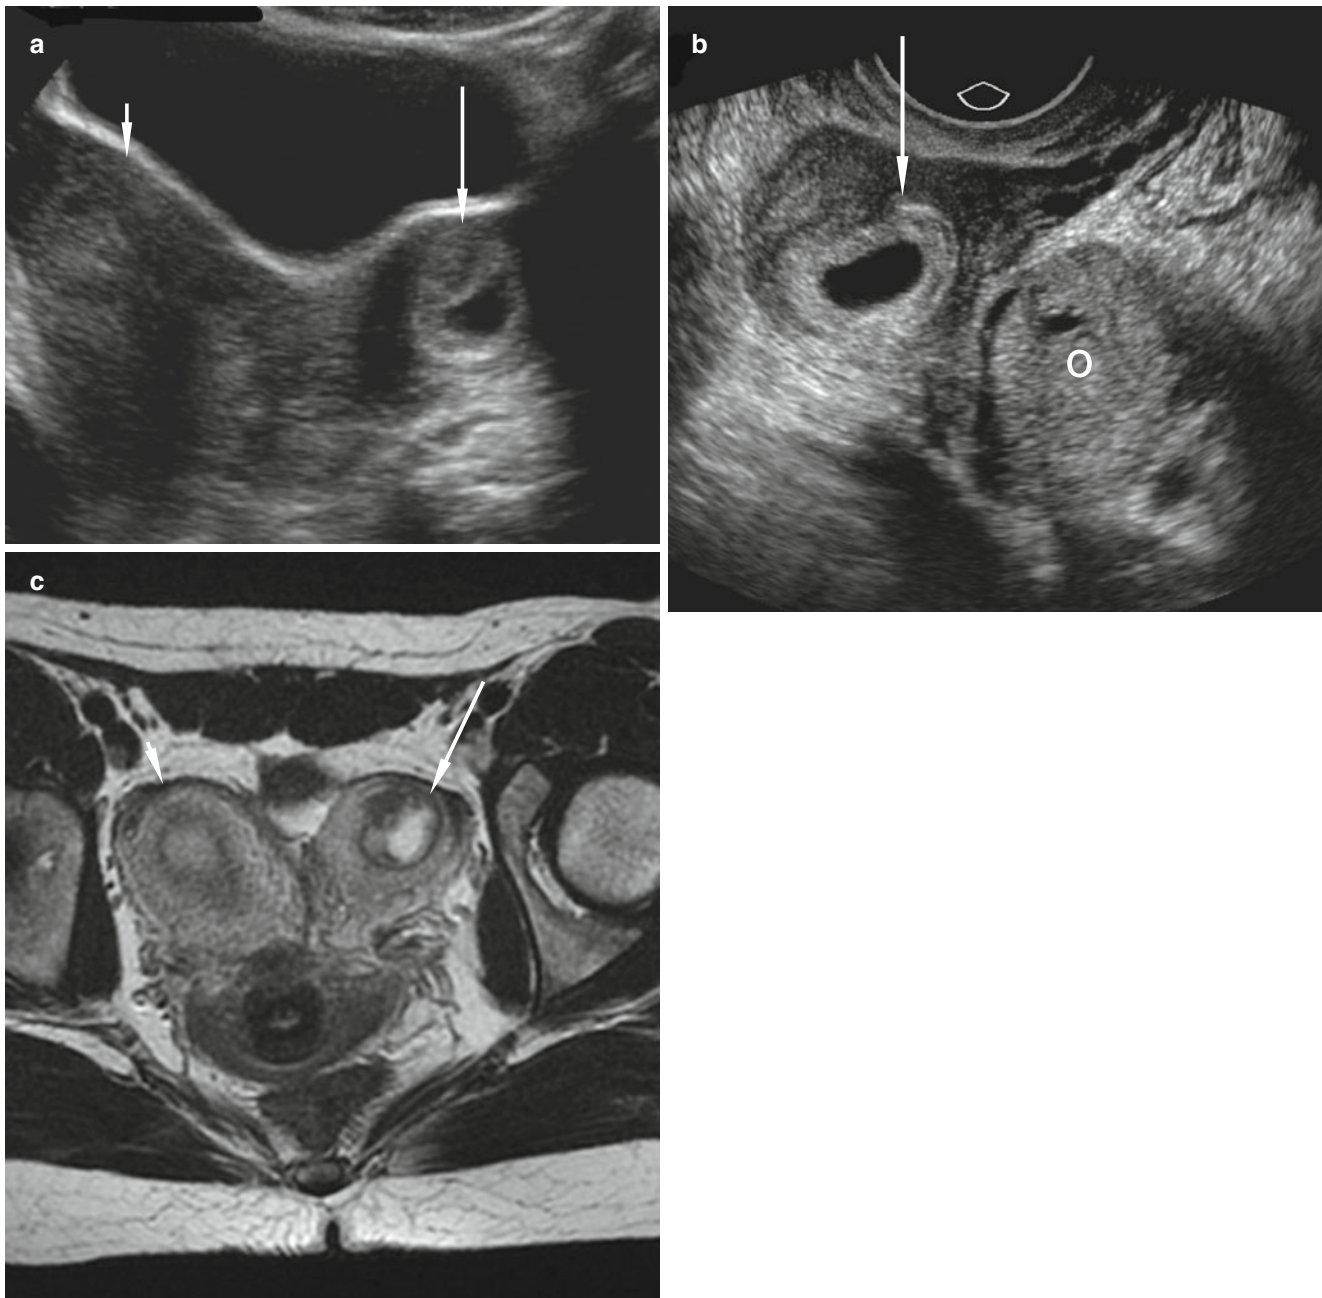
Three images of cornual ectopic (Courtesy of Dr. Deborah Levine, MD, Boston, Massachusetts). (a) Transverse transabdominal sonogram shows a right horn (*short arrow*) and smaller left horn (*long arrow*) with the gestational sac. (b) Transvaginal sonogram shows the pregnancy in the left horn (*arrow*) adjacent to the ovary (*O*). Note how
